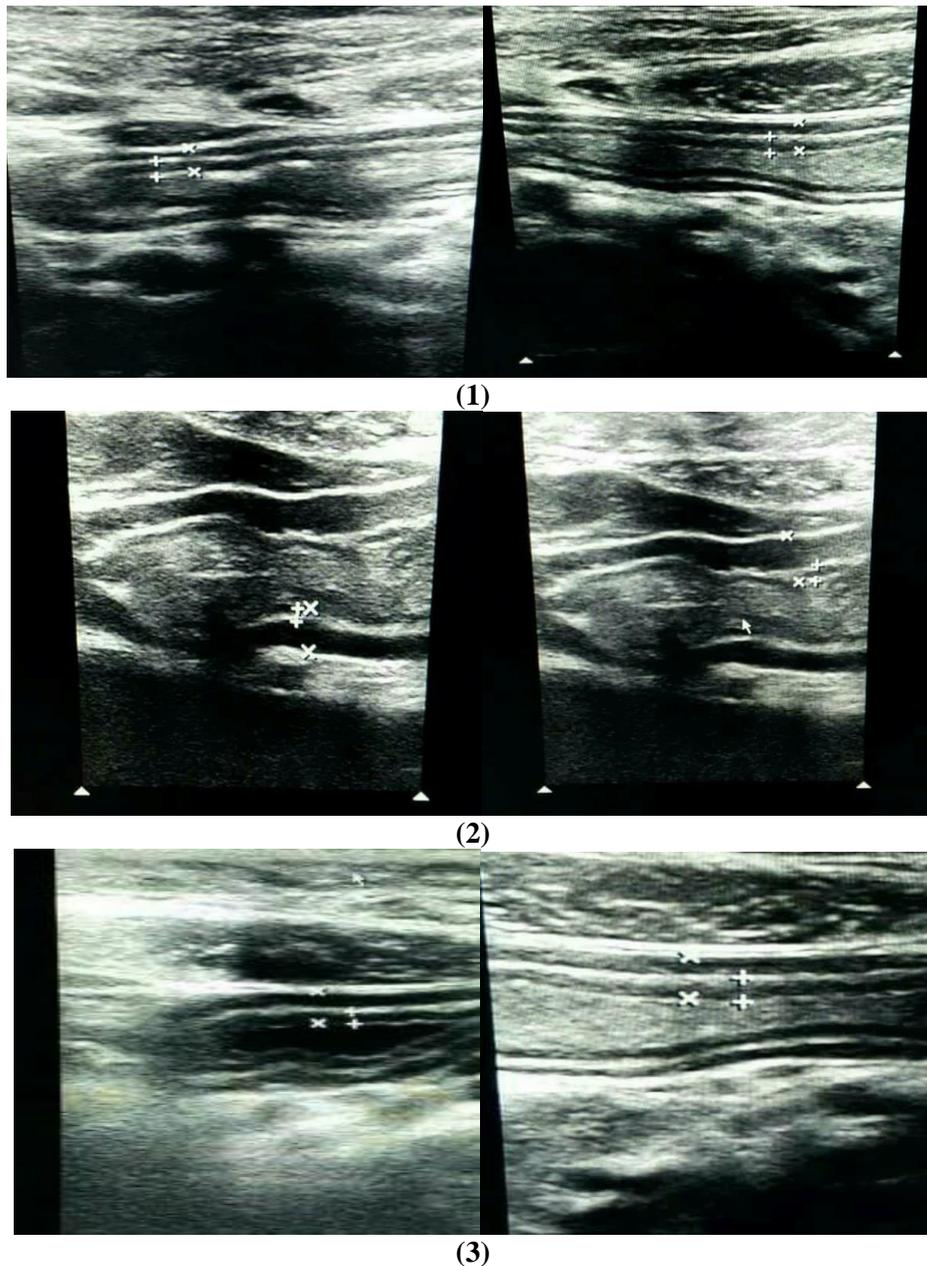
Method of Ultrasonography examination for the stomach and the duodenum [13].
